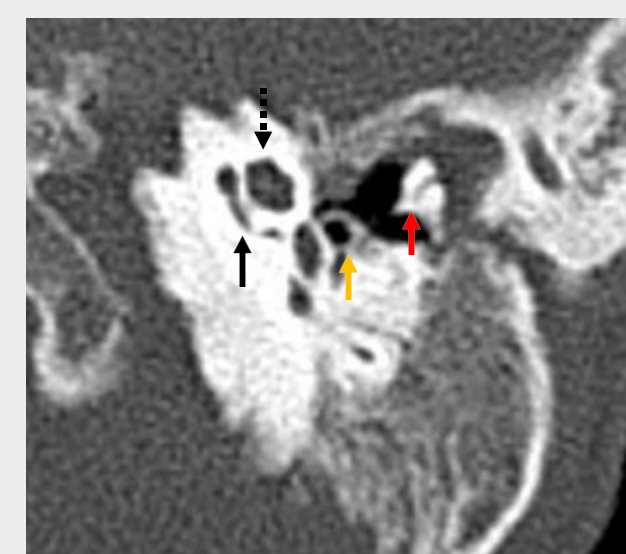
Axial Non-contrast CT Head at Level of Temporal Bones
